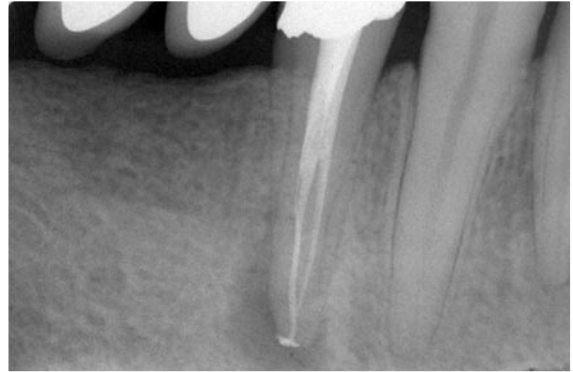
Postoperative radiograph of a lower first premolar with two canals joining at a common foramen.
